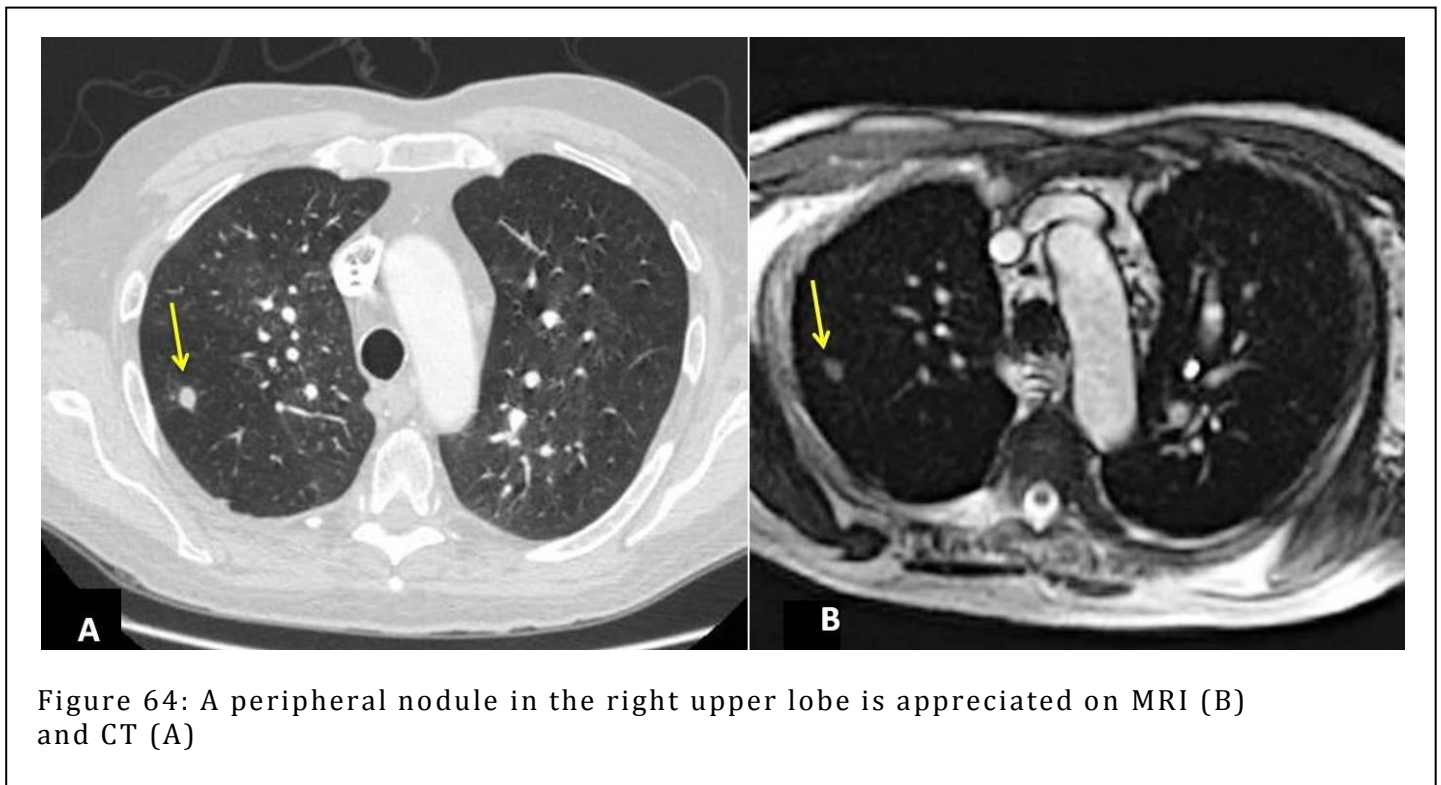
A peripheral nodule in the right upper lobe is appreciated on MRI (B) and CT (A)
